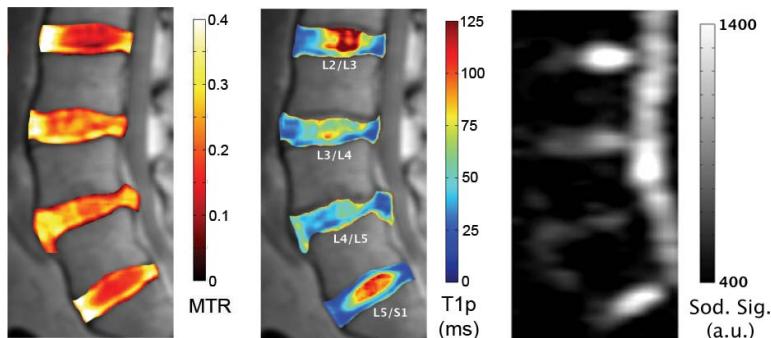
The self-coregistered sagittal lumbar MTR and T_{1p} maps of a 54-year-old subject overlaid on top of the grayscale anatomical image. The sodium MR image of the same subject is shown on the right.
